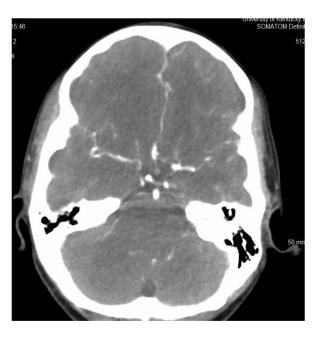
Initial CTA H showing distal left M1 stenosis.
